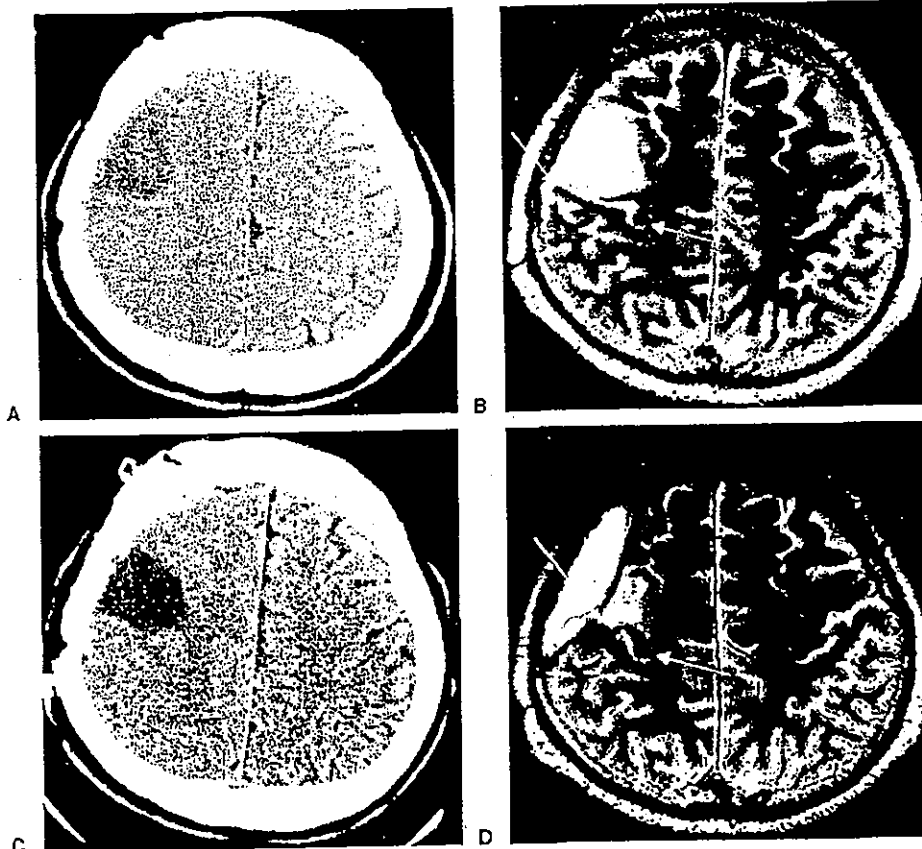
Case 1. Arrows indicate the central sulcus: (A) Preoperative unenhanced computed tomography (CT) scan showing a hypodense glioma close to the central sulcus; (B) Preoperative axial T2-weighted magnetic resonance (MR) image showing the hyperintense glioma; (C) Postoperative CT scan; (D) Follow-up axial T2-weighted MR image.
